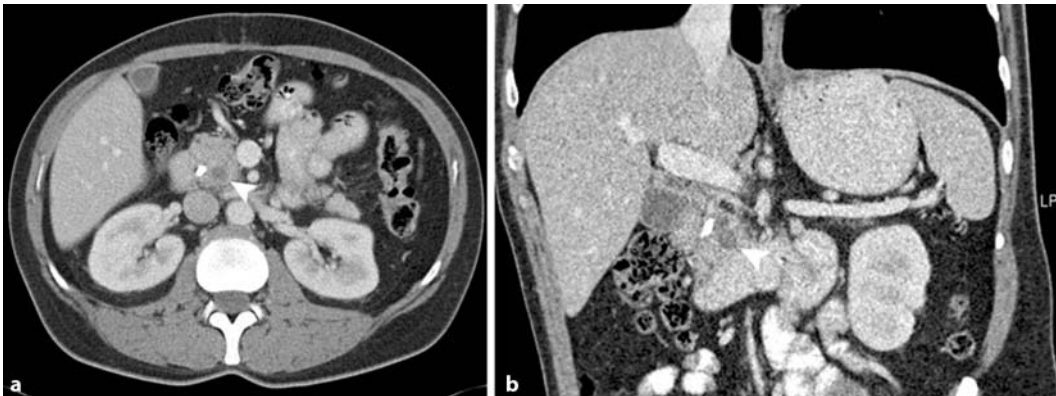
Spiral CT (arterial phase, 35 s after contrast media injection) of the 45-year-old patient with pancreatic carcinoma, before starting palliative chemotherapy. In the axial source image (a) and the oblique coronal reconstruction (b), good delineation of an oval-shaped hypointense mass with a maximum diameter of 3.5 cm (white arrowhead) can be seen within the pancreatic head. Stent prosthesis is located beside the tumor in the common bile duct.
